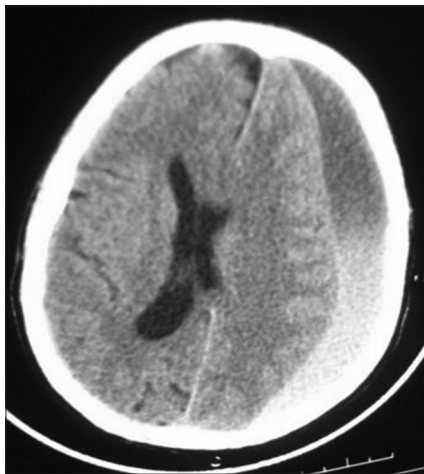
Non-contrast computed tomography of head showing mixed dense chronic subdural hematoma
